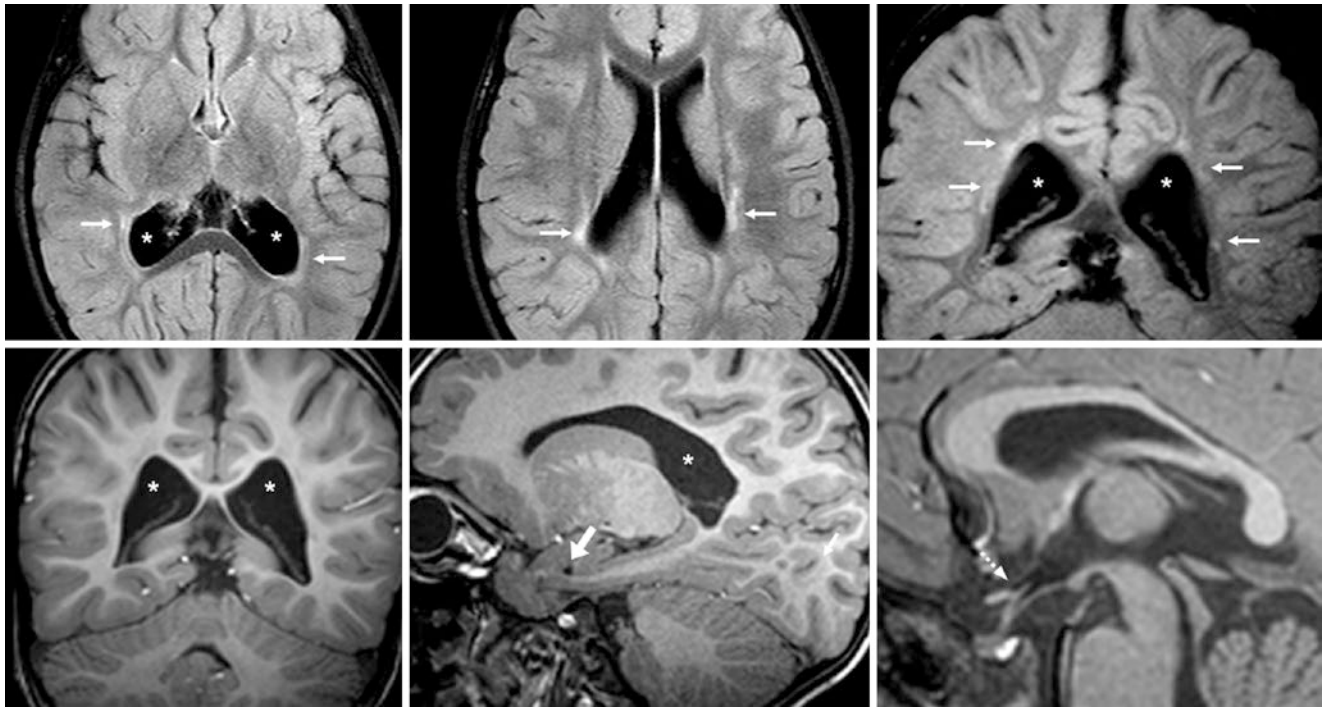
Comparison case of PVL. In a 3 year old, a 3T MRI showed mildly enlarged posterior bodies (*) of the lateral ventricles on axial FLAIR (top left and middle), coronal FLAIR (top right), coronal T1WI (bottom left), and sagittal T1WI (bottom middle and right). Note the hyperintense and thinned PVWM (thin arrows). Both the temporal horns (arrow) and optic recess (dotted arrows) appear normal, excluding hydrocephalus
